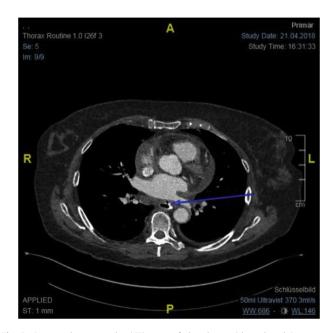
Computed tomography (CT) scan of the chest with oral and intravenous contrast showing contained esophageal perforation CT scan with contrast done 17 days after the ablation shows a mid esophageal perforation. There is extravasation of oral contrast media from the esophagus (blue arrow) into the mediastinal space in short distance to the left superior pulmonary vein. There is no visible connection to the left atrium or the pulmonary veins.
